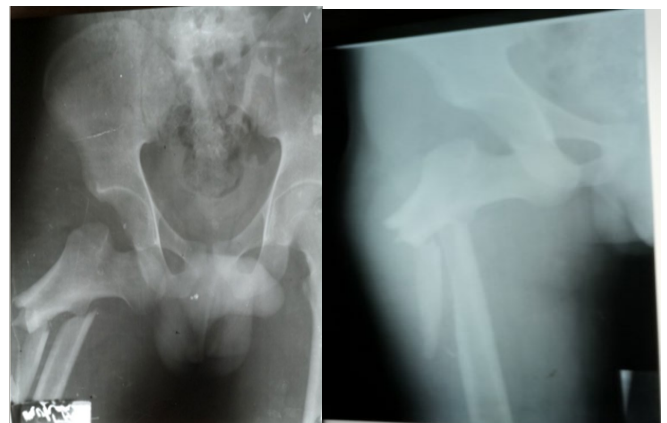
AP x-ray showing sub trochanteric femur fracture with ipsilateral Obturator type anterior hip dislocation.
